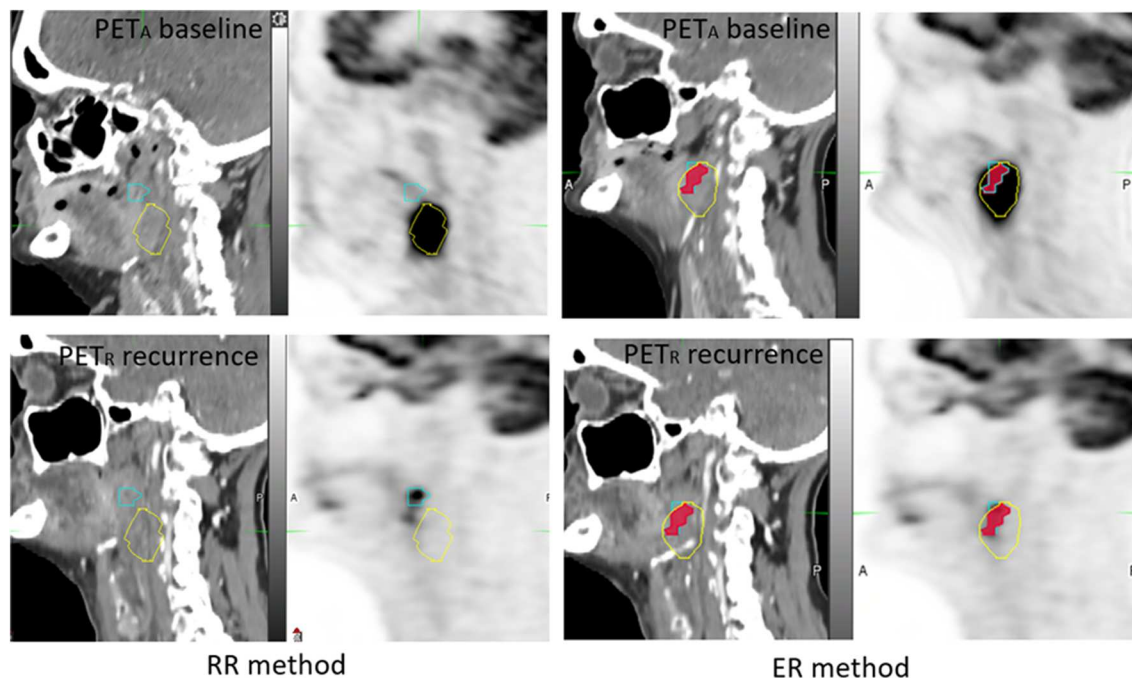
Example of 65 year-old woman, with T3N1M0 oropharyngeal squamous cell carcinoma. Before the emergence of reflex otalgia and neck pain, a PET-CT was performed 2 months after radiotherapy and showed a local persistent disease. PET_A (images on the top) and PET_R (images on the bottom) were not scanned in treatment position (NTP) and coregistered with RR method (on the left) and ER method (on the right). A₄₀ subvolume (yellow line), R₄₀ subvolume (blue line) and A₄₀ ∩ R₄₀ (red area). The OF (A₄₀, R₄₀) index was calculated respectively at 0 and 0.80 for RR and ER registration methods.
